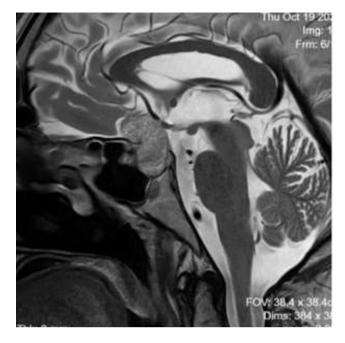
MRI pituitary gland images showing a pituitary macroadenoma
